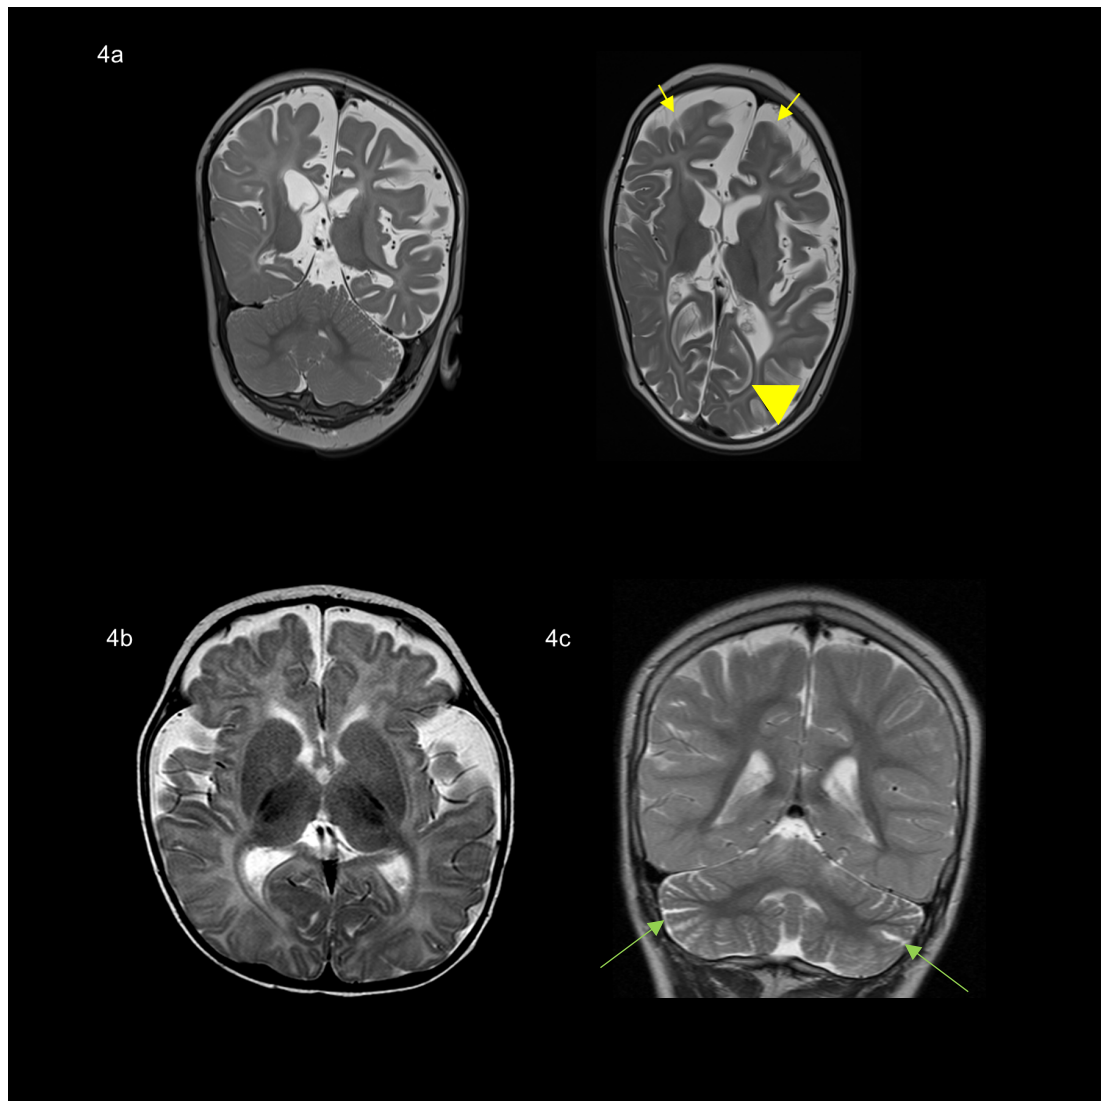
MRI features in KCNT1-related epilepsy
